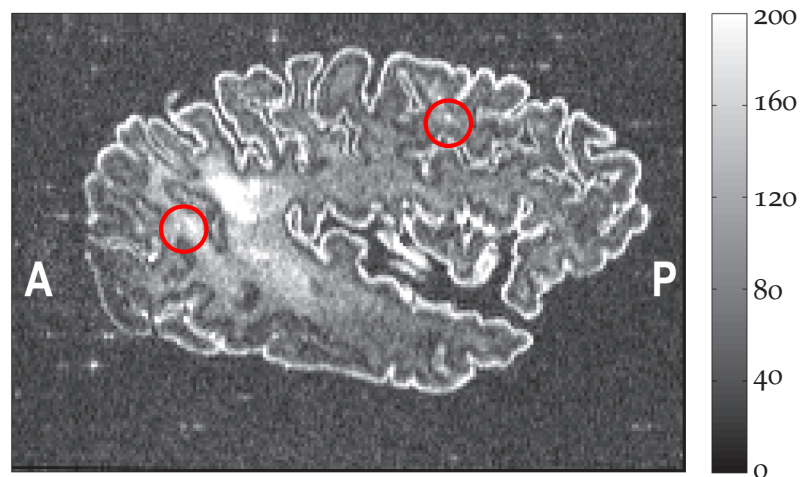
Artifacts in images of the unfixed human hemisphere acquired after 1.5h of continuous imaging using the Panini coil (red circles and bright spots around the sample). Imaging had to be aborted to avoid damage to the coil and MRI hardware.
